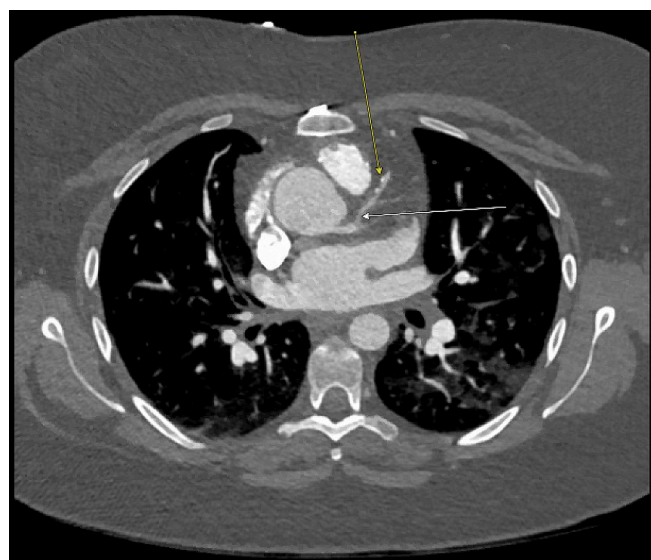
Coronary CT angiogram demonstrating severe left anterior descending coronary artery disease (arrows).
